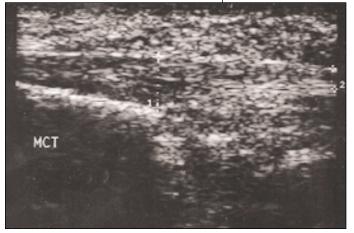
Ultrasound imaging of normal medial band of the plantar fascia. The vertical line labeled "1" shows the relatively narrow width of the normal plantar fascia.
